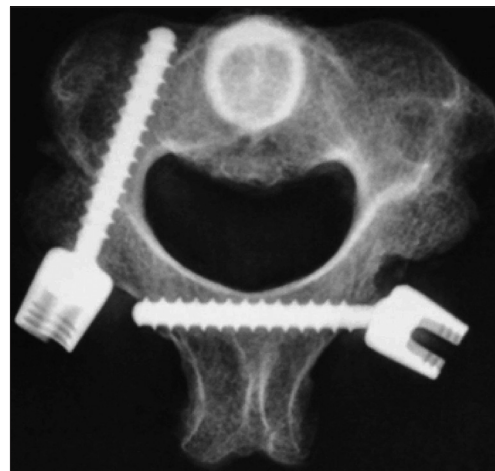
Computed tomography scan showing placement of C2 spinous process screw (left) and pedicle screw (right)
